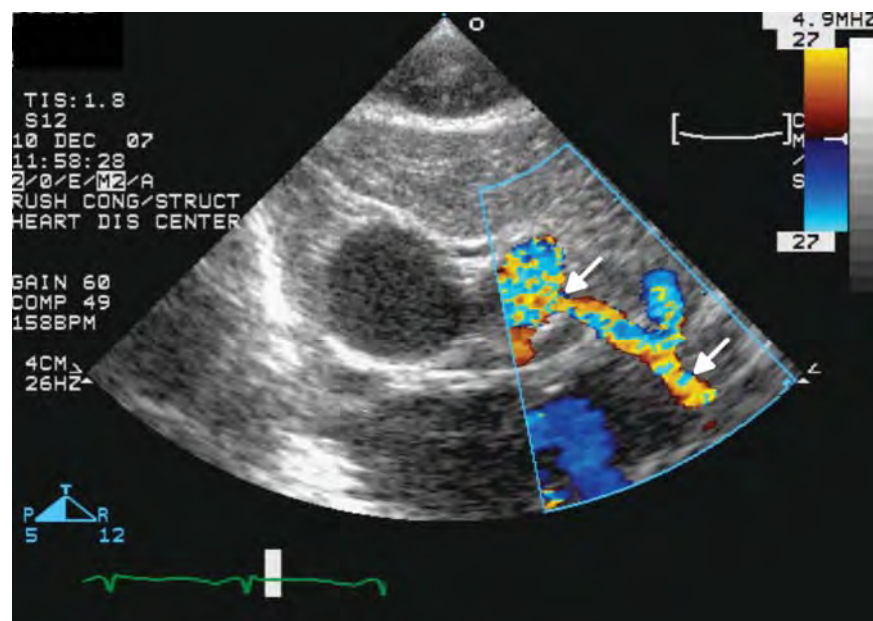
Parasternal short axis view with color Doppler demonstrating reversal of flow in the dilated coronary sinusoids with areas of multiple constrictions (white arrows).
